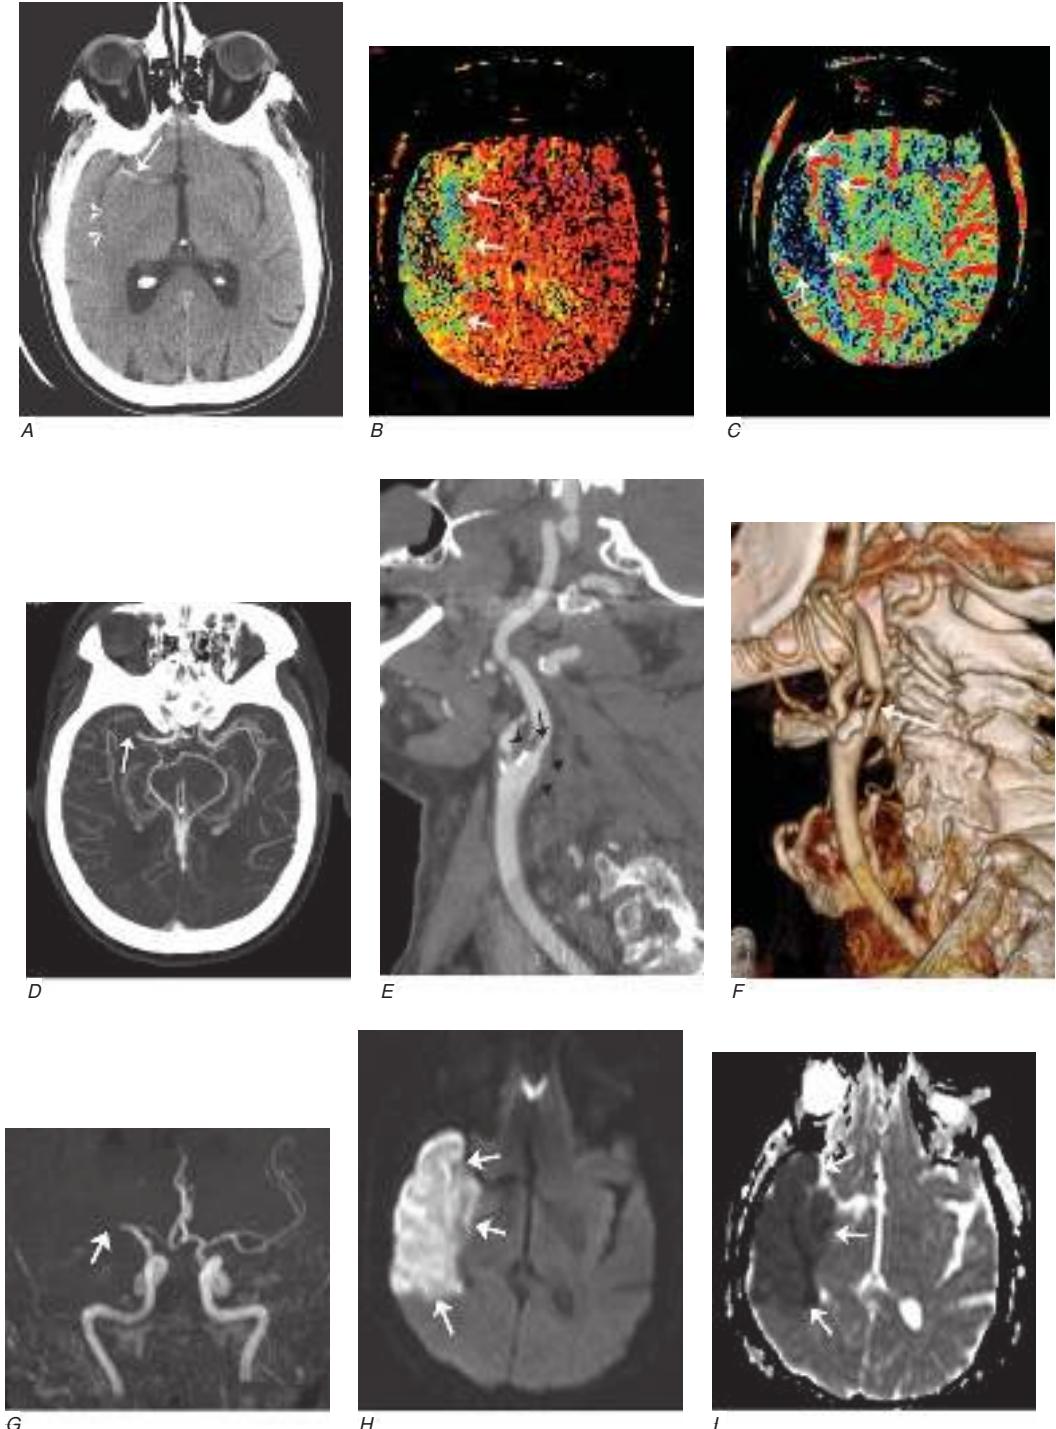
Acute left hemiparesis due to right middle cerebral artery occlusion. *A*, Axial noncontrast computed tomography (CT) scan demonstrates high density within the right middle cerebral artery (arrow) associated with subtle low density involving the right putamen (arrowheads). *B*, Mean transit time CT perfusion parametric map indicating prolonged mean transit time involving the right middle cerebral territory (arrows). *C*, Cerebral blood volume (CBV) map shows reduced CBV involving an area within the defect shown in *B*, indicating a high likelihood of infarction (arrows). *D*, Axial maximum-intensity projection from a CT angiography (CTA) study through the circle of Willis demonstrates an abrupt occlusion of the proximal right middle cerebral artery (arrow). *E*, Sagittal reformation through the right internal carotid artery demonstrates a low-density lipid-laden plaque (arrowheads) narrowing the lumen (black arrow). *F*, Three-dimensional surface-rendered CTA image demonstrates calcification and narrowing of the right internal carotid artery (arrow), consistent with atherosclerotic disease. *G*, Coronal maximum-intensity projection from magnetic resonance angiography shows right middle cerebral artery (MCA) occlusion (arrow). *H* and *I*, Axial diffusion-weighted image (*H*) and apparent diffusion-coefficient image (*I*) document the presence of a right middle cerebral artery infarct.
